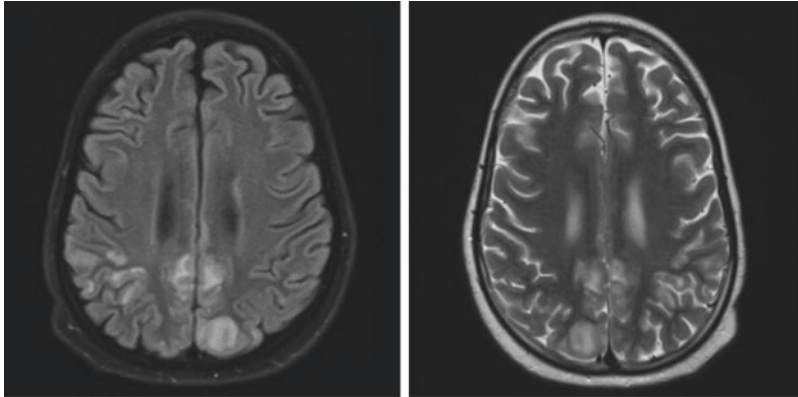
MRI images showing symmetrical regions of T2 prolongation involving the cortex and subcortical white matter of the cerebral hemisphere, most pronounced in the parietal and occipital lobes
